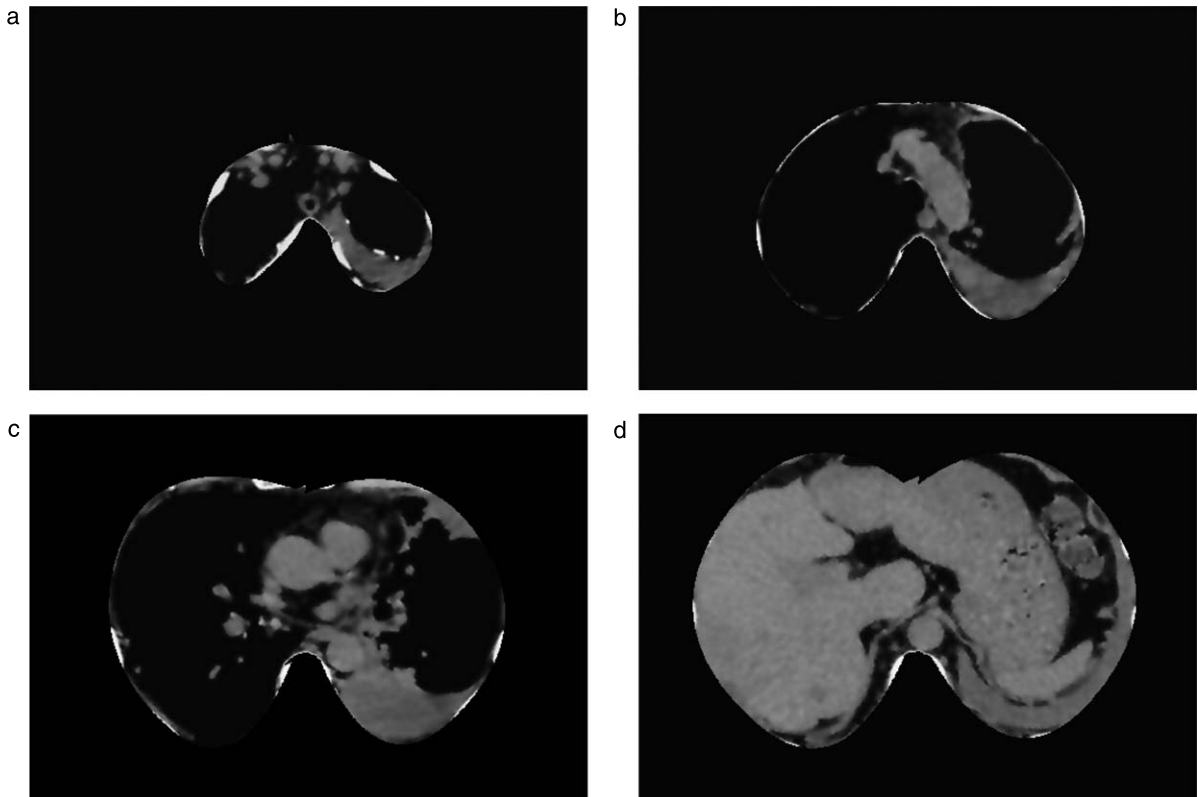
The images with the inner chest wall boundary in different CT scans.
